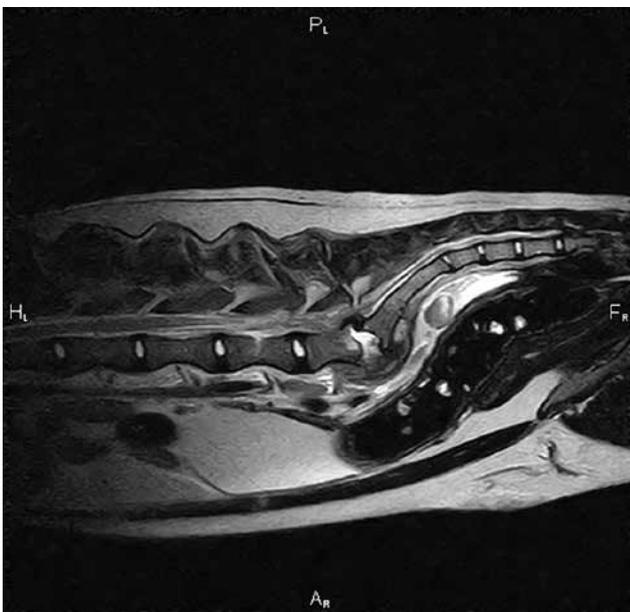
Sagittal T2-weighted magnetic resonance image of the lumbosacral region. Note the widening of the intervertebral disc space at L7-S1, with irregular appearance of the endplates and abnormal hyperintense signal and dorsal herniation of the intervertebral disc.
